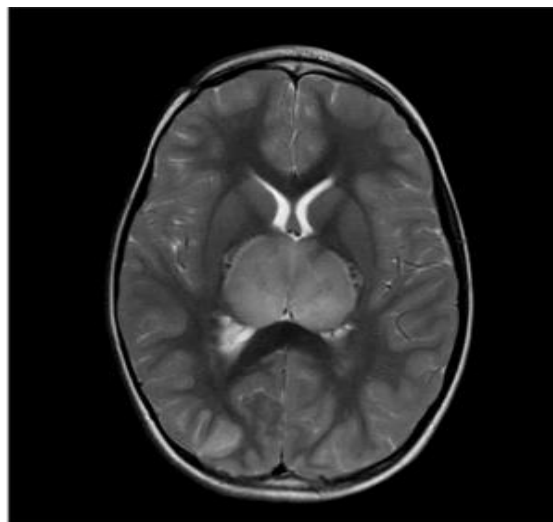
Brain MRI axial T2 sequence shows extensive symmetrical bilateral thalamic swelling.
